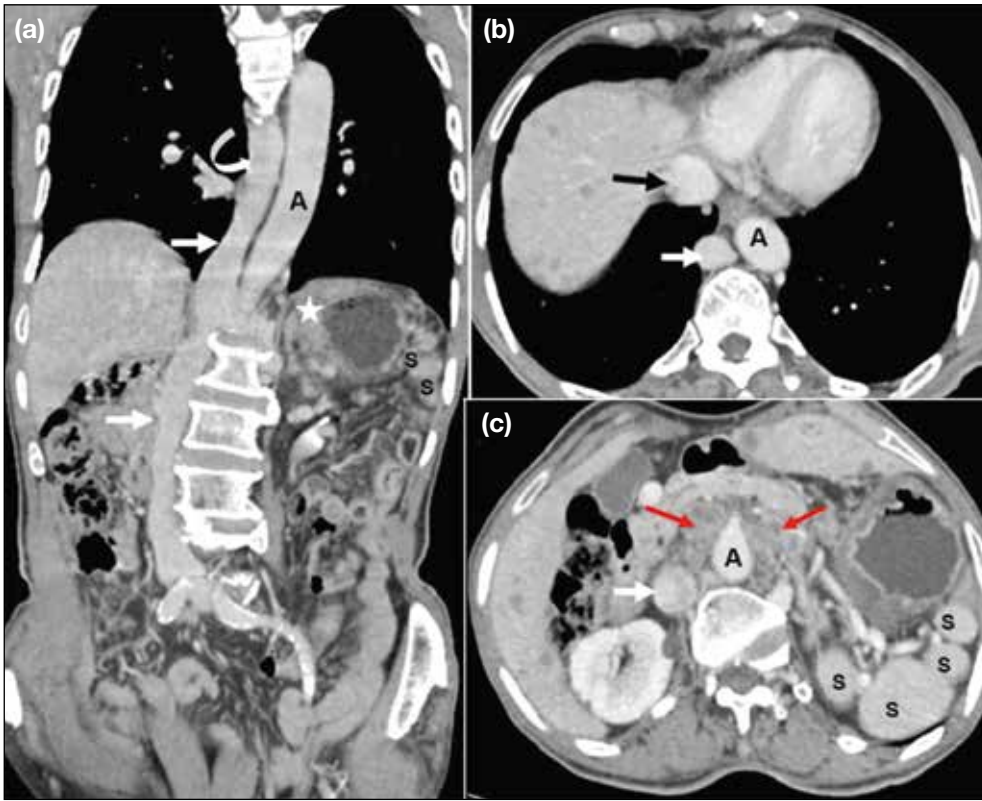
Coronal (a) and axial (b, c) contrast-enhanced computed tomography images in a patient with gastric malignancy (star in [a]) show polysplenia (S) and a right inferior vena cava with azygos continuation (white arrows) draining into the superior vena cava (curved arrow in [a]). Hepatic veins drain separately into the right atrium (black arrow in [b]), and para-aortic lymphadenopathy is also noted (red arrows in [c]). Abbreviation: A = aorta.
